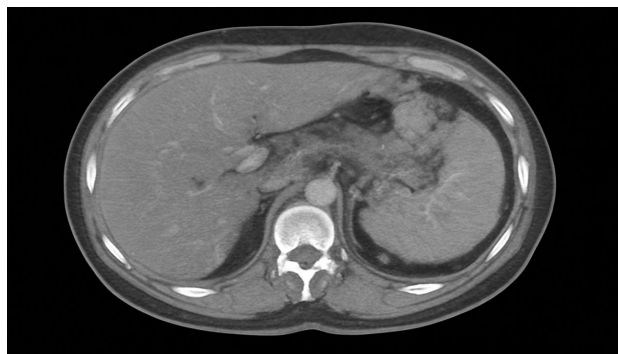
contrast- enhanced CT abdomen showing peripancreatic inflammatory changes consistent with acute pancreatitis
